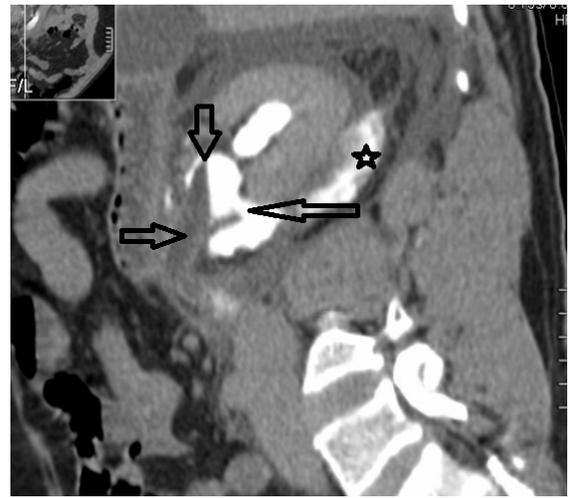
56 year old male patient with spontaneous rupture of renal pelvis secondary to lower ureteric calculus Delayed phase obtained at 10min, Oblique sagittal CT view showing rupture of the renal pelvis (left arrow), non opacified ureter (right arrow), contrast fluid level in the pelvis(down arrow) and perinephric collection (five point star)
